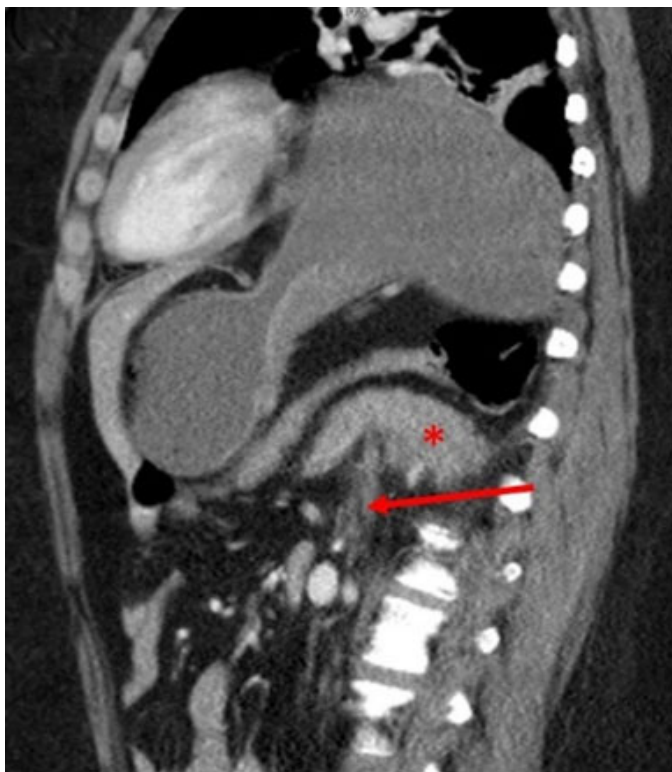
CT abdomen and pelvis with IV contrast sagittal view. Herniation of pancreatic tail above (shown in red asterisk) the left hemidiaphragm (marked in red arrow).
